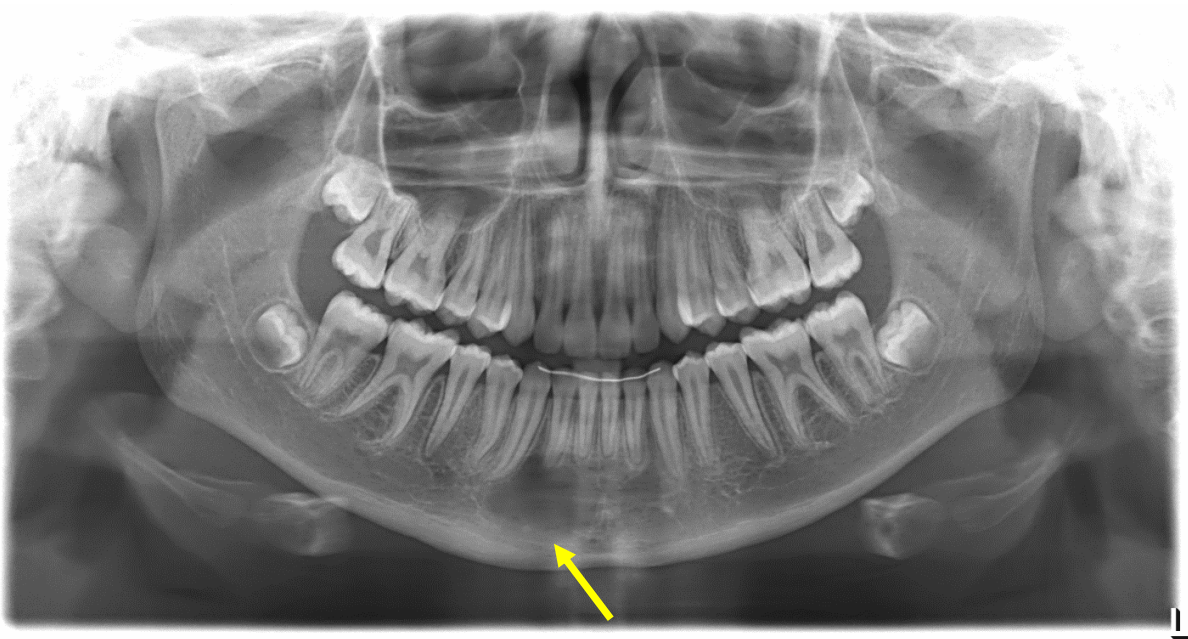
Example of CBCT demonstrating expansion not seen on PAN
